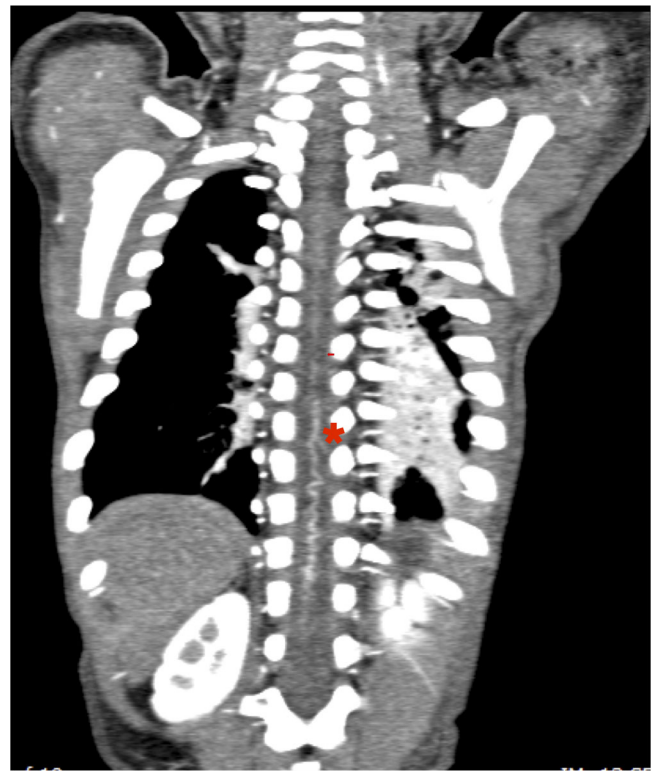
Dynamic airway computed tomography angiogram with artery of Adamkiewicz (AoA) protocol. The AoA is the primary blood supply to the thoracolumbar spine; the aorta supplies the AOA, which feeds the anterior spinal artery. Oblique coronal 1.3- to 1.5-mm-thick maximum intensity projections are reconstructed from the phase where the AoA is identified. The AoA is identified as a classic "hairpin loop" (red asterisk) within the spinal canal as it arises from an intercostal artery and feeds into the anterior spinal artery.
